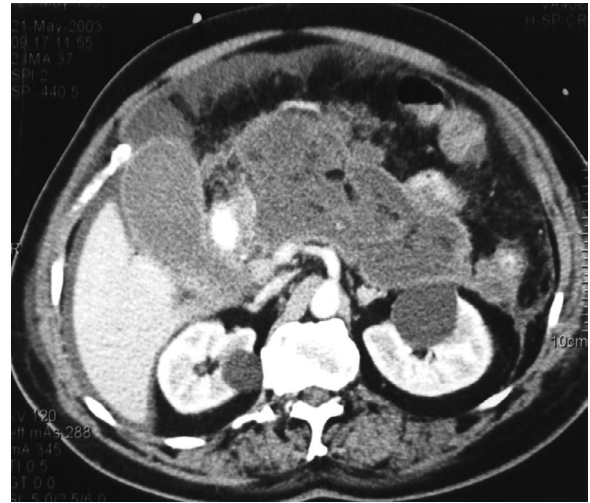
■ Computed tomography scan of a patient with severe necrotizing pancreatitis and Balthazar grade E scan; more than 50% necrosis of the gland was seen on previous scans of the gland, giving the patient a Balthazar index of 10.
